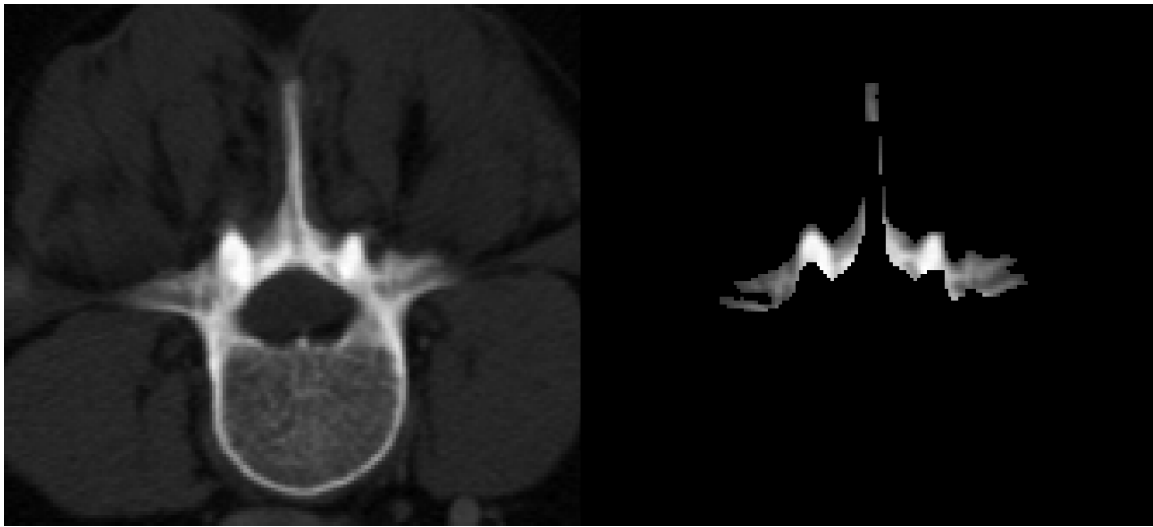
Axial view of a CT image (left) and its corresponding extracted bone surface (right).
